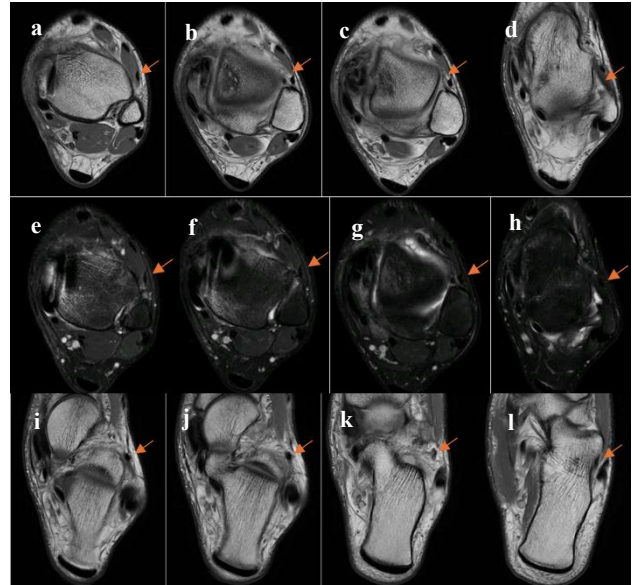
(a-l): MRI axial sequences in T1 and T2, evidencing the AFCM (orange arrow).
